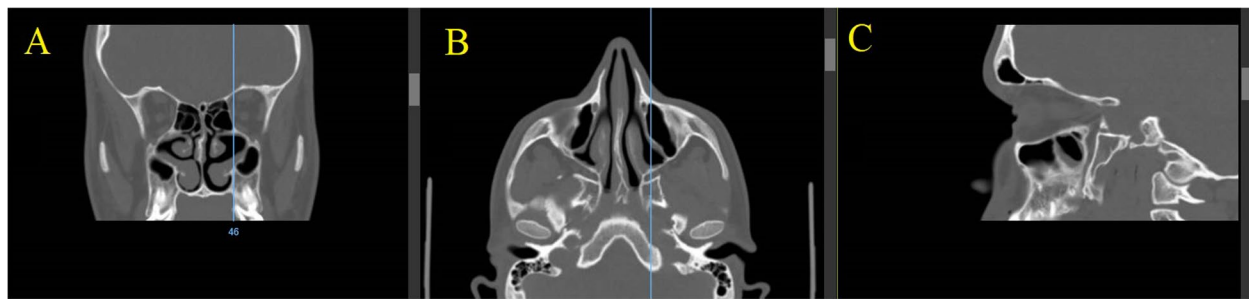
CT shows bilateral retro-maxillary nasal recesses at coronal cut (A), axial cut (B), and sagittal cut (C)
